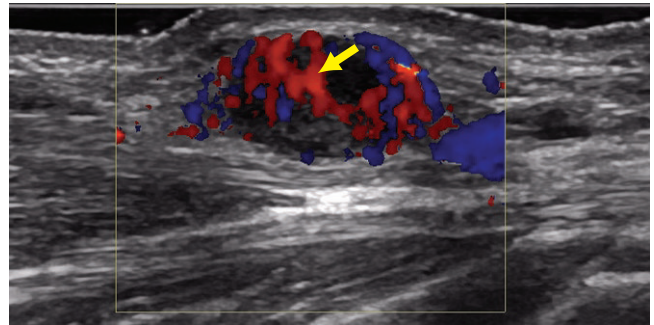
The sagittal image of the volar aspect of the forearm shows a hypoechoic mass in the subcutaneous tissues with marked internal vascularity (arrow) on color Doppler.
